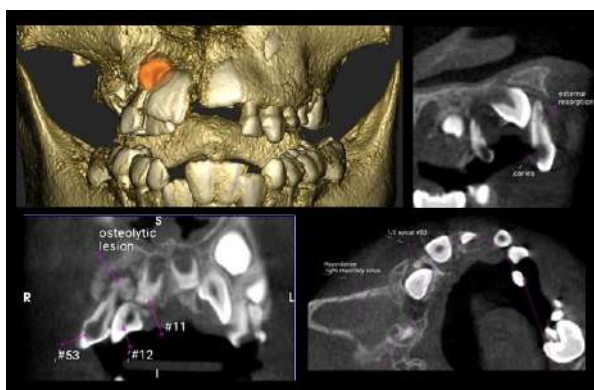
3D reconstruction, axial, sagittal and coronal view of 3D CBCT images with small FOV of 9-year-old female patient showing #53 with osteolytic lesion because of infection from the caries and the right maxillary sinus shows condition of inflammation
